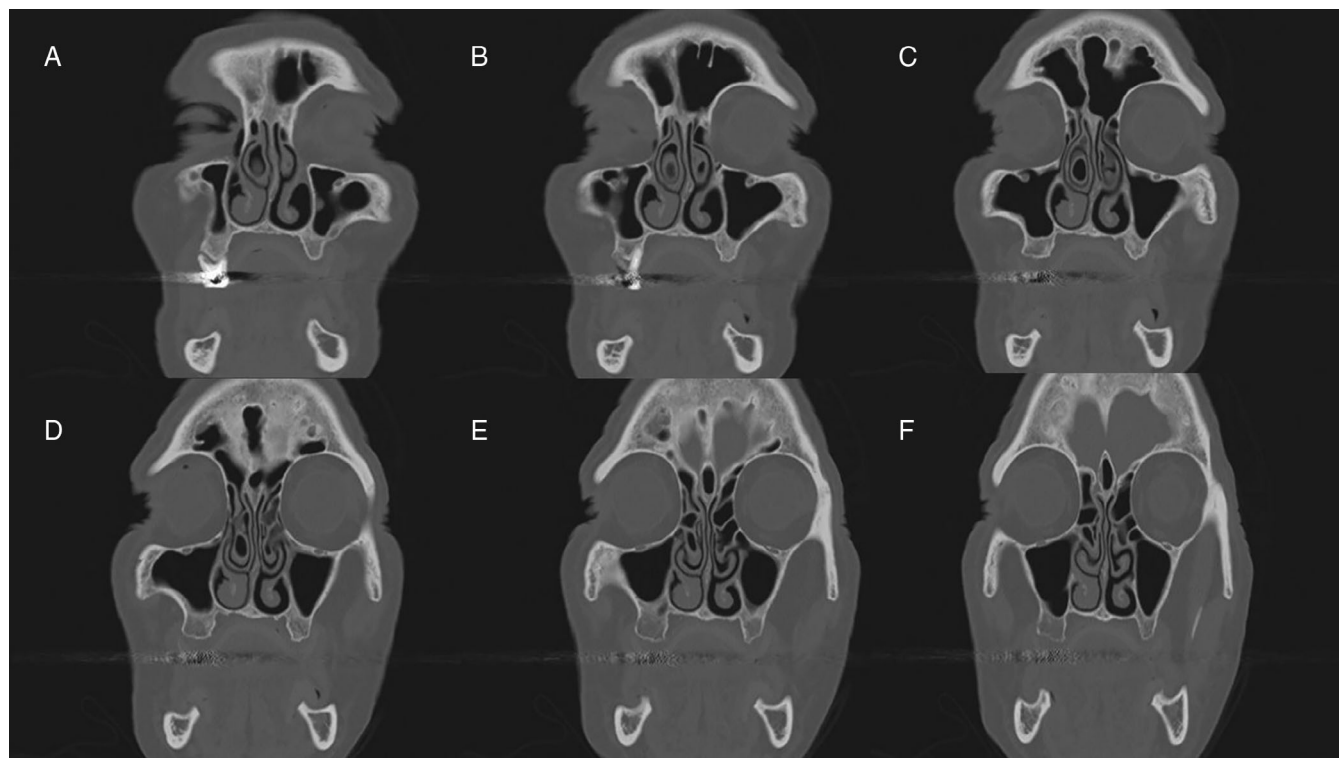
CT scan sections demonstrating that both external and internal concha bullosa are connected directly to the skull base and lamina papyracea.
